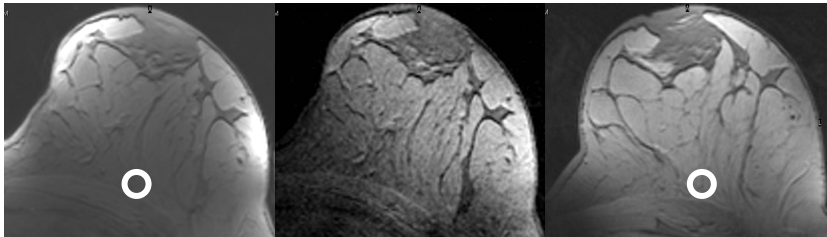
MRI images from the same breast of a healthy volunteer obtained with the 30 channel surface array (a), the enlarged transmit coil integrated in the 30 channel array (b), and an SNR optimized 2 channel transceiver (c). At the worst case location in the breast (white circle), the SNR of the MRI in a is comparable to c.
